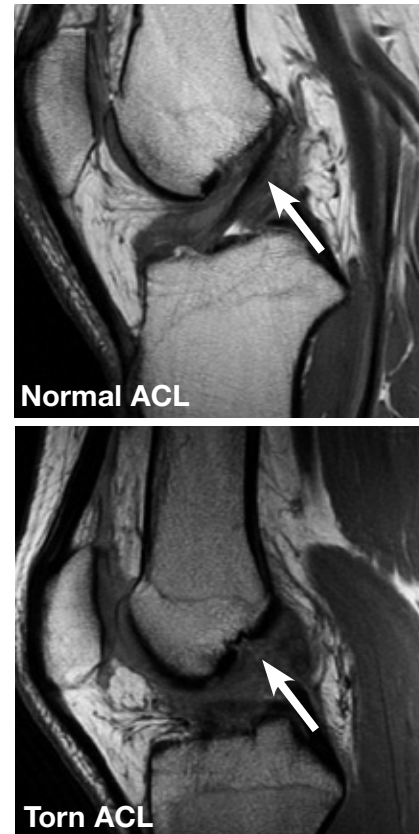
MRI images of the ACL of the knee
